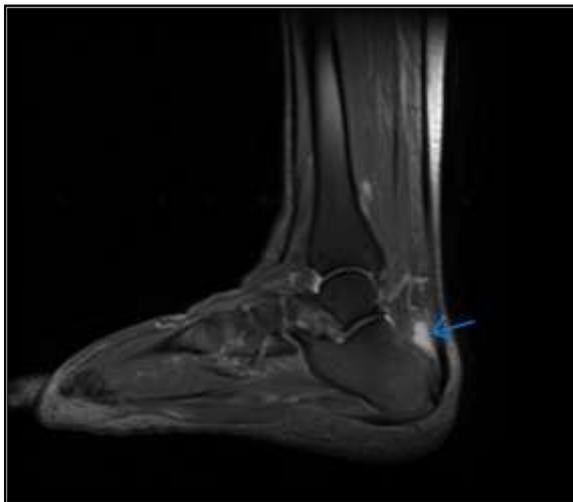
Sagittal PD fat-saturated MRI of the ankle
